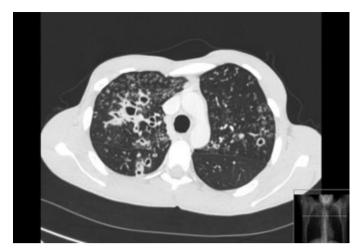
CT chest showing consolidation with cavitation and bronchiolar ('tree-in-bud') changes.
